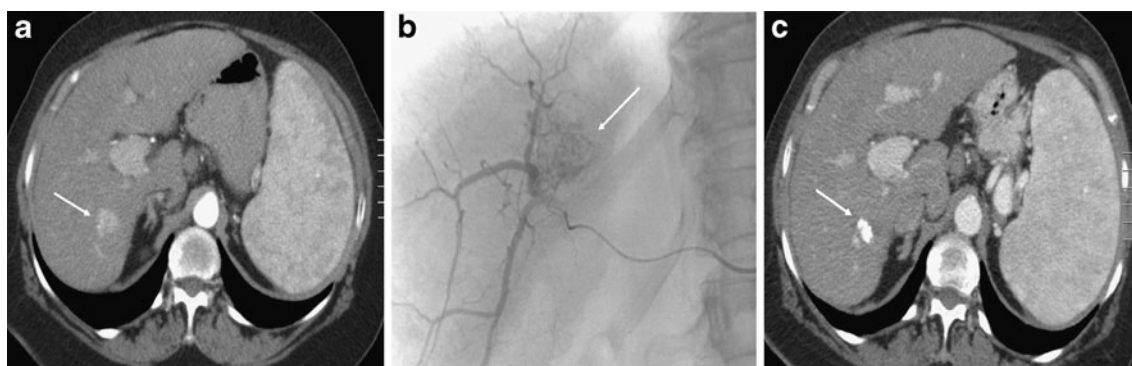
“Bridging therapy” of hepatocellular carcinoma (HCC) with transarterial chemoembolization (TACE) a: Contrast enhanced CT examination shows typical arterial enhancement of a HCC nodule
